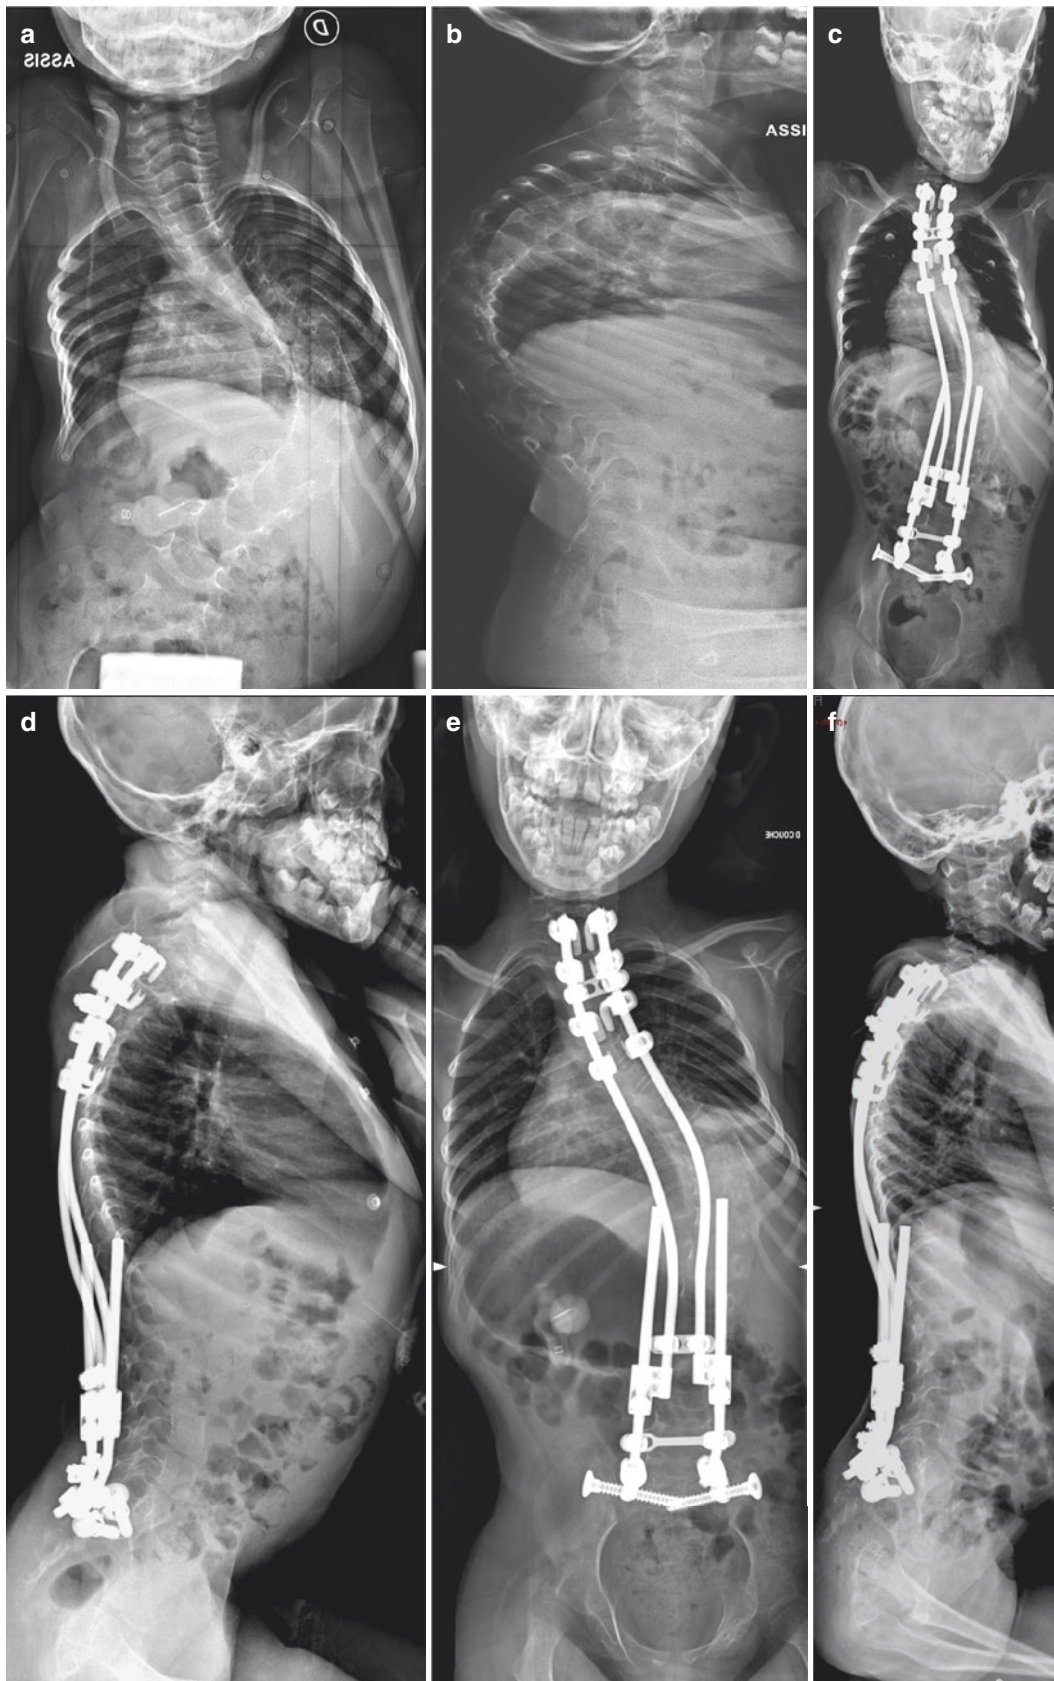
Case of spinal muscular atrophy in a 6-year-old patient. Preoperative radiographs (a, b), postoperative (c, d), 1 year postoperative (e, f), after cross-link removal (g, h), 2 years after cross-link
